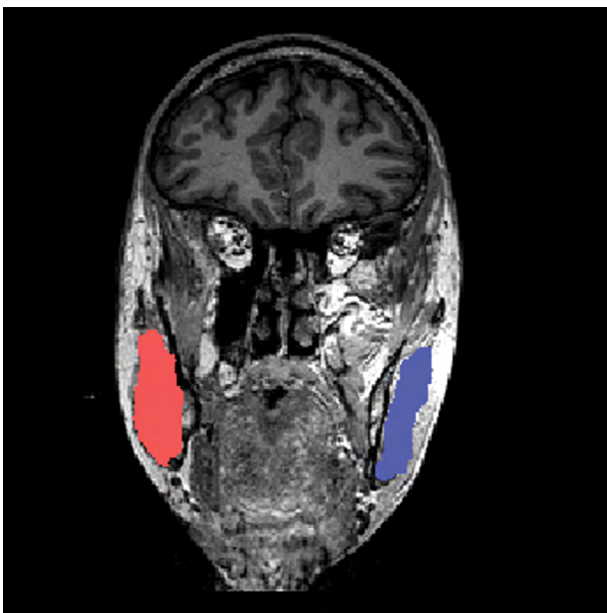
Example of magnetic resonance imaging volumetric analysis.
